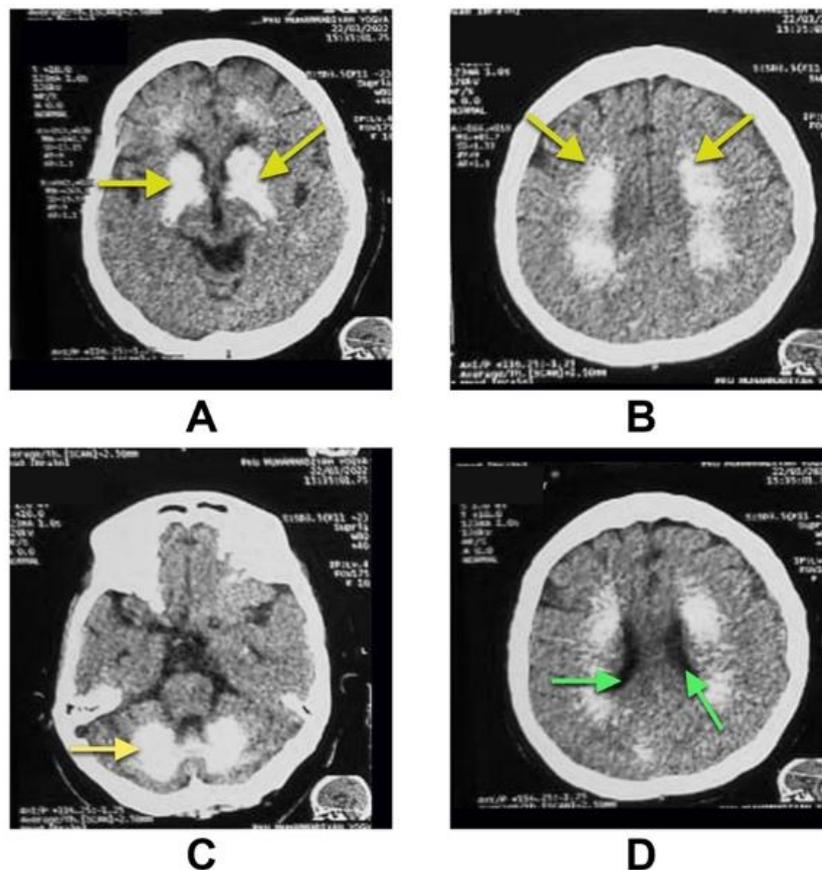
Head CT scan of the patient showing bilateral and symmetrical calcification of the BG (A), corona radiata (B), and cerebellar hemispheres (C). There is a mild bilateral dilatation of lateral ventricles (D)
